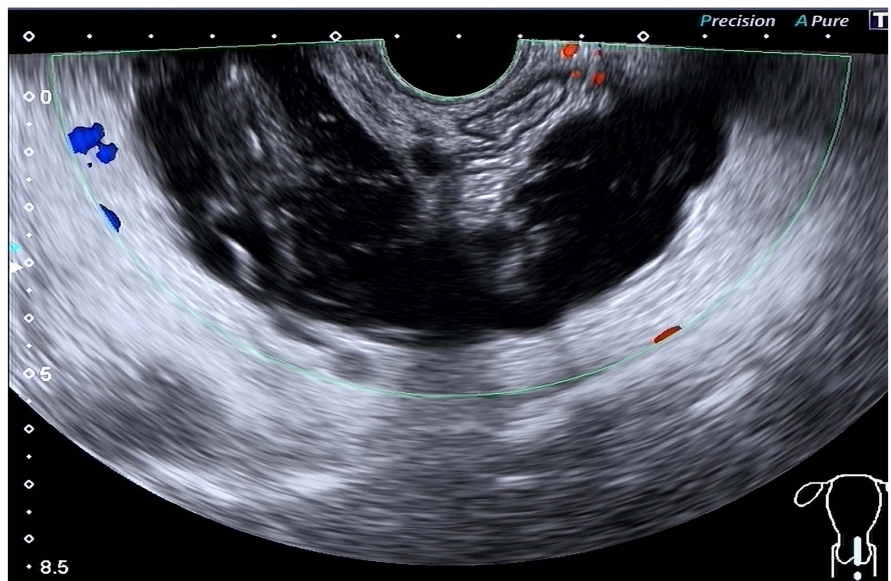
Color ultrasound image: The pelvic colloid-like effusion shows multilocular changes, and no obvious blood flow signals are detected inside.
